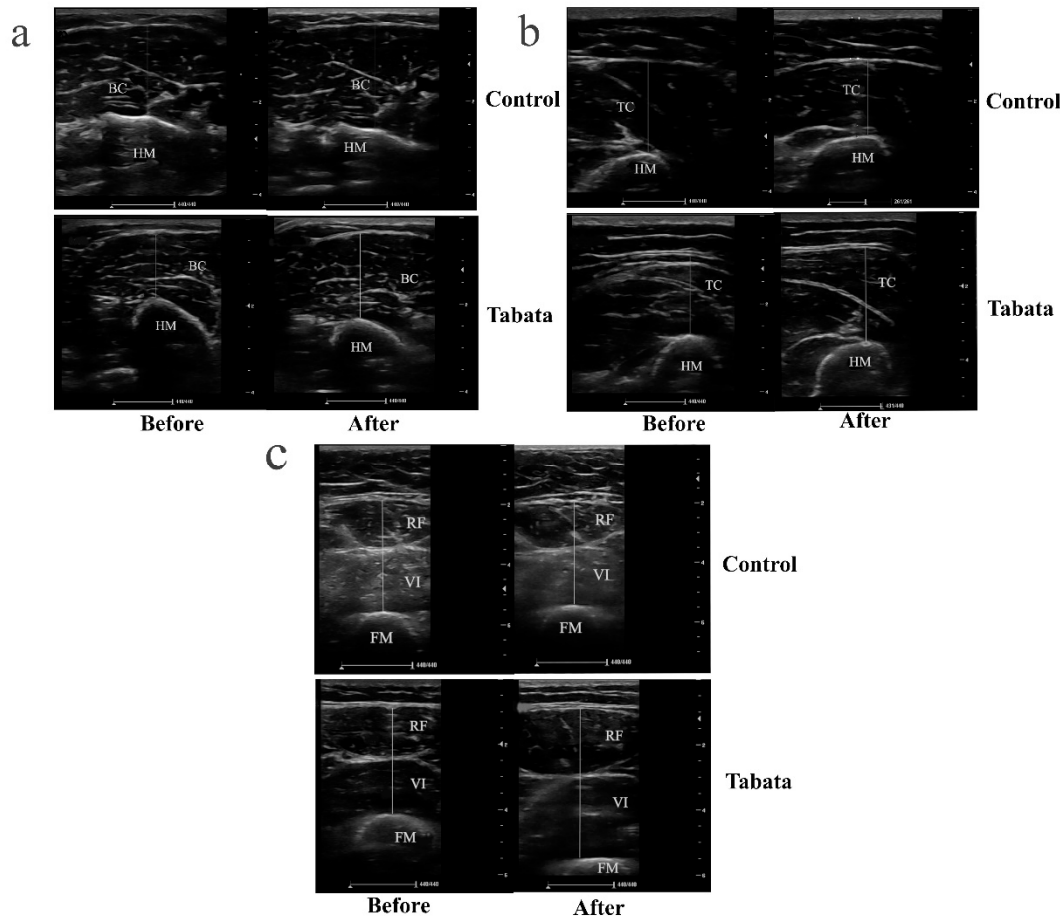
Ultrasound imaging demonstrates muscle thickness of participants in control and Tabata groups before and after 12-weeks intervention. (a) a transverse scan of biceps muscle (BB), with the hyperechoic, curvilinear structure in the lower part of the image representing the humerus (HM). (b) a transverse scan of triceps muscle (TC), where the hyperechoic, curvilinear structure in the lower part of the image corresponds to the HM. (c) a transverse scan of quadriceps muscle, comprising the rectus femoris (RF) and vastus intermedius (VI); the hyperechoic, curvilinear structure in the lower part of the image represents the femur (FM). The solid straight lines indicate the method used to measure the thickness of each muscle.
